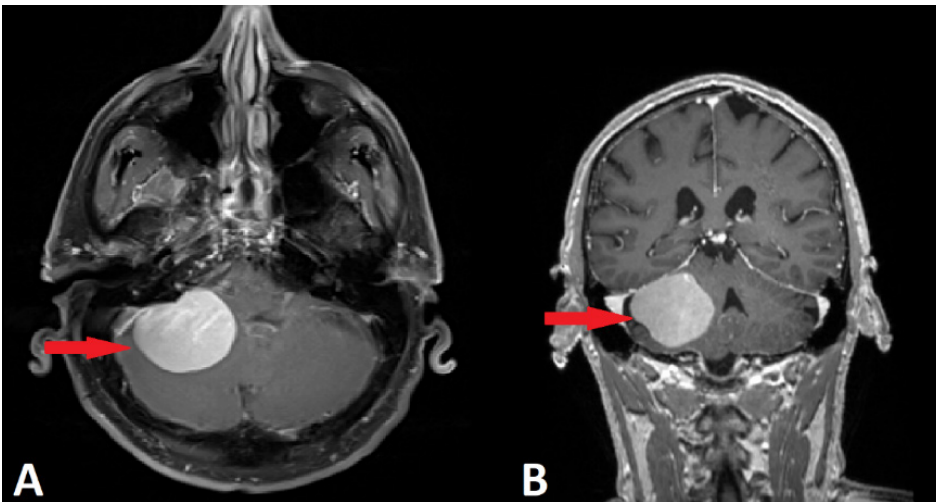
Axial and coronal head MRI scans with contrast (A and B) demonstrate a large bright extra-axial mass (red arrows) within the right cerebellopontine angle, consistent with a meningioma with a rounded contour and a dural attachment, displaying mass effect upon the right cerebellar hemisphere, with flattening of the lateral wall of the fourth ventricle and mild displacement to the left of midline.
